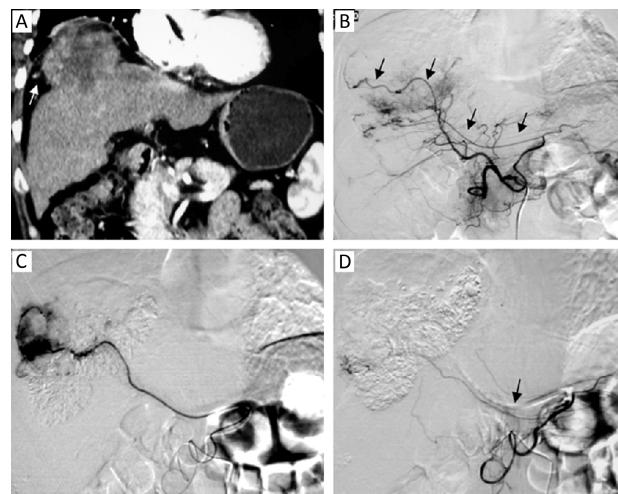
HCC supplied by POA in a 60-year-old women. A: Abdominal CT scan in hepatic arterial phase shows: the tumor breaks through the liver capsule, showing exogenous growth, an enlarged artery near the tumor edge (white arrow); B: Celiac artery angiography shows enlarged POA nourishes the edge of the tumor (black arrow); C: The 2.7F microcatheter was successfully used to perform the superselective catheterization for the POA. The tip of a microcatheter is beyond the stomach artery; D: After chemoembolization to the POA, another POA was found, however, it was too fine to fail the superselective catheterization.
